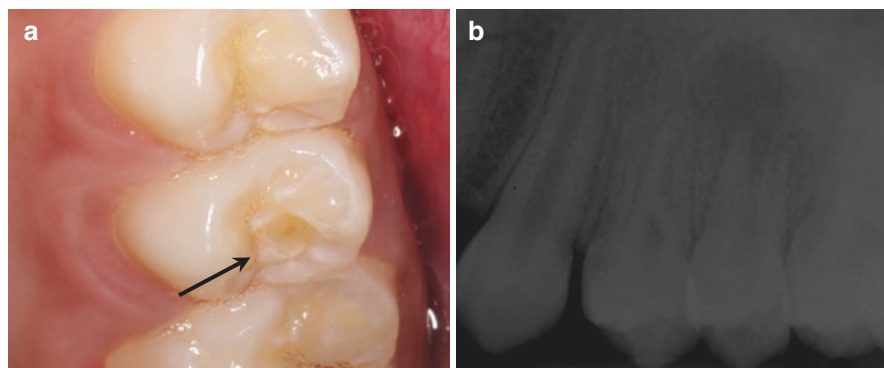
(a) Fractured dens evaginatus on the upper left second premolar. (b) Periapical radiograph of the same child, showing a periapical radiolucency related to ED on the immature tooth
